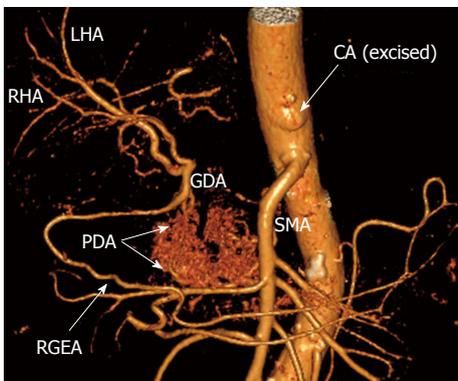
Three-dimensional computed tomography-angiography following distal pancreatectomy with excision of celiac artery and its branches. Blood supply to liver and stomach is delivered from superior mesenteric artery (SMA) via pancreaticoduodenal arcade (PDA) and then through gastroduodenal artery (GDA). There is robust right gastro-epiploic artery (RGEA) appearing in its entirety. RHA: Right hepatic artery; LHA: Left hepatic artery; CA: Celiac axis; GDA: Gastroduodenal artery.
